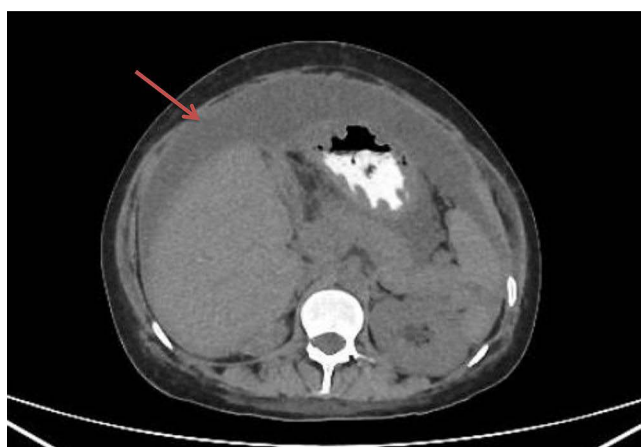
CT scan showed massive ascites with thick enhancing walls, the red arrow indicates ascites.
